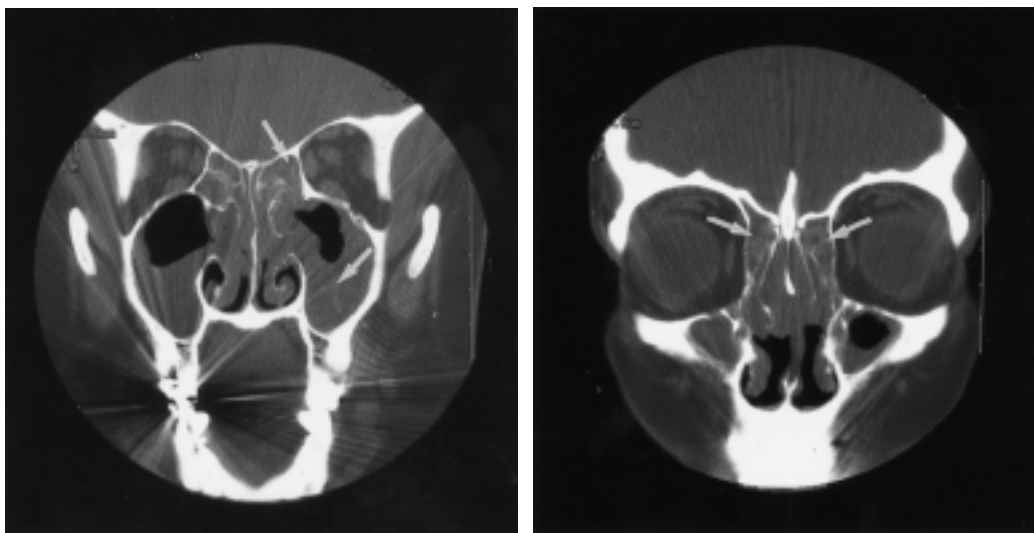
Coronal computed tomographic scans from 2 different patients with chronic rhinosinusitis showing moderate inflammatory thickening and typical small areas of high attenuation (arrows) correlating with the intraoperative finding of eosinophilic (allergic) mucin.
